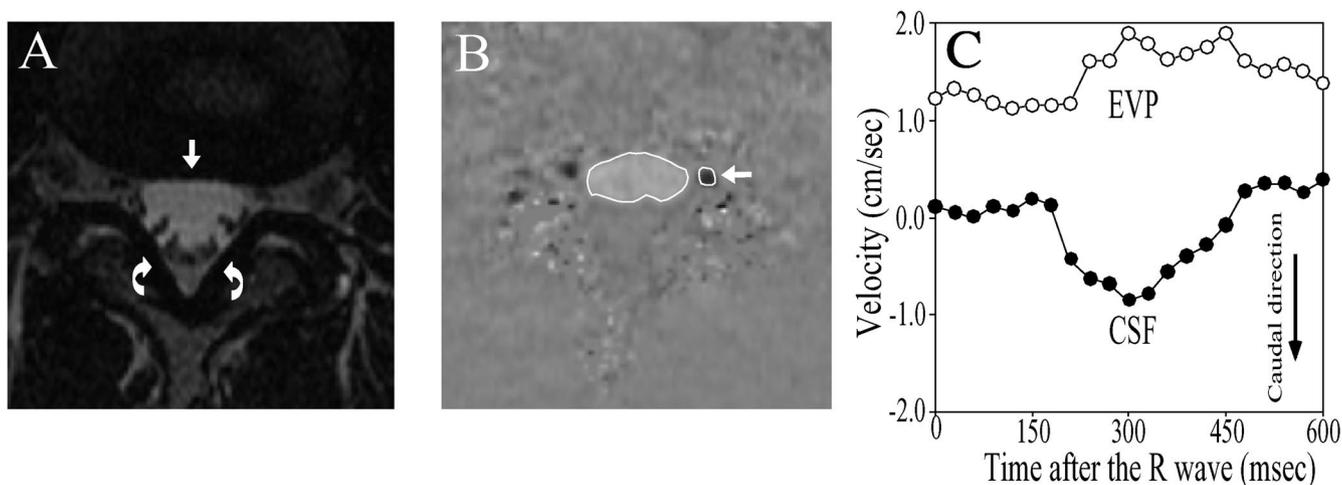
Examples of magnetic resonance images used to determine various measurements and graph representing velocities. (A) Axial image at the L3–L4 intervertebral foramen level showing bright cerebrospinal fluid (CSF) containing nerve roots observed as gray defects and triangle-shaped posterior epidural fat (*curved arrow*). The perimeter of the CSF (*straight arrows*) was measured to determine the dural surface area. The area of the posterior epidural fat was measured to determine the posterior epidural fat volume. The CSF perimeter and the posterior epidural fat areas at this level were 0.52 cm and 0.15 cm², respectively. (B) Axial image of CSF and epidural venous plexus (EVP) flows at the L3–L4 disk level. Bright imaging indicates caudad flow, and dark imaging indicates cephalad flow. Cephalad EVP flow (*straight arrow*) is observed adjacent to caudad CSF flow. The regions of interest were defined by tracing the outlines of CSF and EVP, seen as bright and dark, respectively. (C). Graph representing CSF and EVP velocities (cm/s) after the R wave. The negative deflections represent caudad systolic CSF flow, whereas the positive deflections represent cephalad diastolic CSF flow. Therefore, the CSF velocity profile had both caudad systolic and cephalad diastolic components. On the other hand, the EVP velocity profile had a mostly cephalad component.
